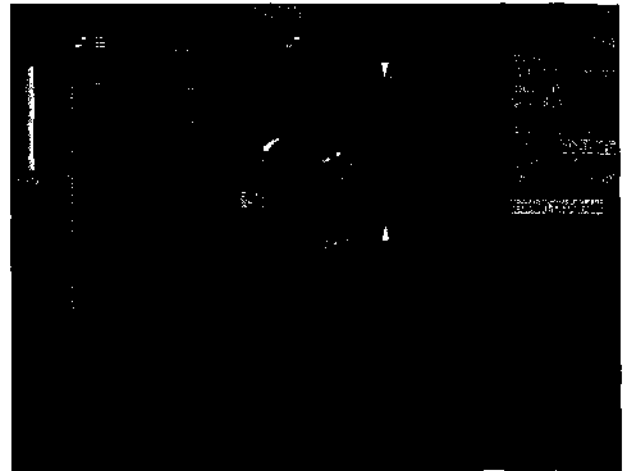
Appendicitis. In this patient with right iliac fossa pain, the hyperemic mass on ultrasound (arrowheads) corresponded with the point of maximum tenderness. The mass is the dilated inflamed appendix lying immediately inferior to the gas-containing cecum. There is no periappendicular collection to suggest an abscess. An uncomplicated acutely inflamed appendix was removed laparoscopically. (See Plate 1.)
